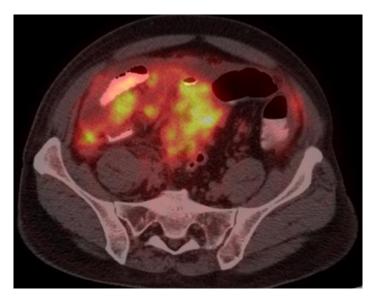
showing FDG avid peritoneal deposits along serosal surface of recto-sigmoid colon & ileal loops with SUV value 17.9
